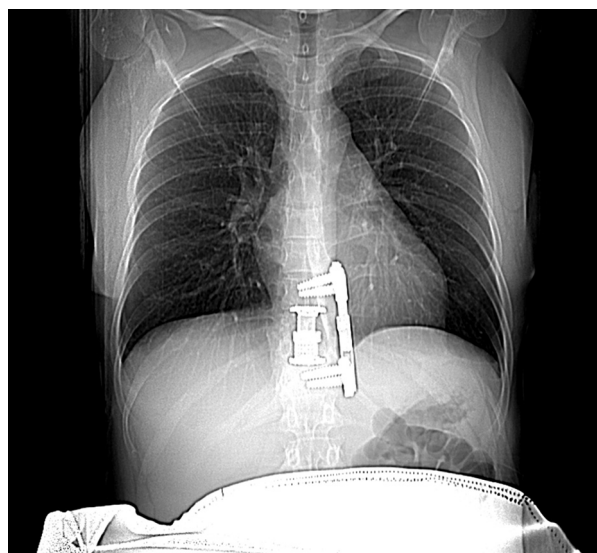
Chest X-ray before therapy without signs of active pulmonary tuberculosis
